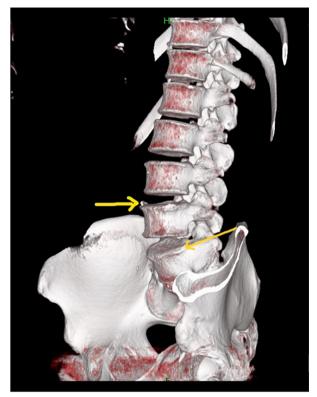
Sagittal view non-contrast CT scan of the lumbar spine using volume rendering technique (VRT) showing syndesmophytes over L4 and L5 vertebrae (yellow arrows).
